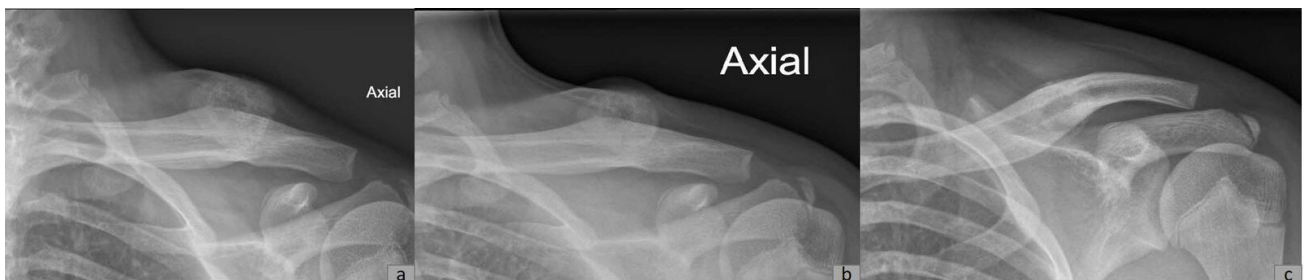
Radiography (axial view) of the left shoulder taken 2 months (a), 3 months (b) and 6 months (c) after the patient initially presented. The continual radiography showed the spontaneous resolution of the mass.
